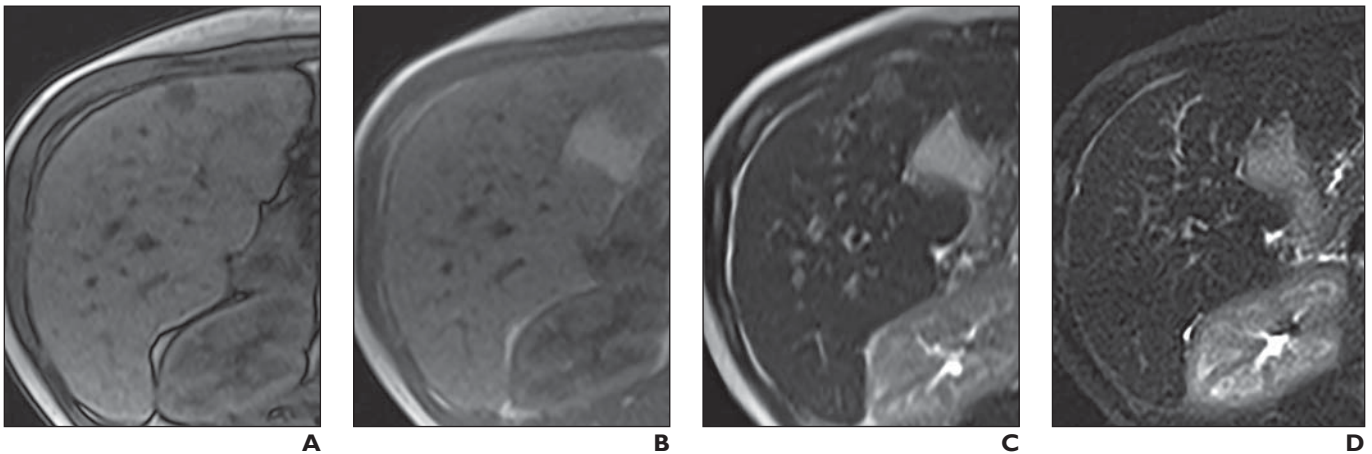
8-year-old boy with benign steatotic nodules. Small nodule exhibits loss of signal intensity on T1-weighted out-of-phase MR images compared with in-phase images. Lesion has increased signal intensity on T2-weighted single-shot fast spin-echo images but is isointense in relation to liver on T2-weighted fat-suppressed images. No hyperenhancing components are present, and lesion remains of diminished signal intensity in all phases after contrast injection. These nodules were stable on follow-up examination 5 years later.
